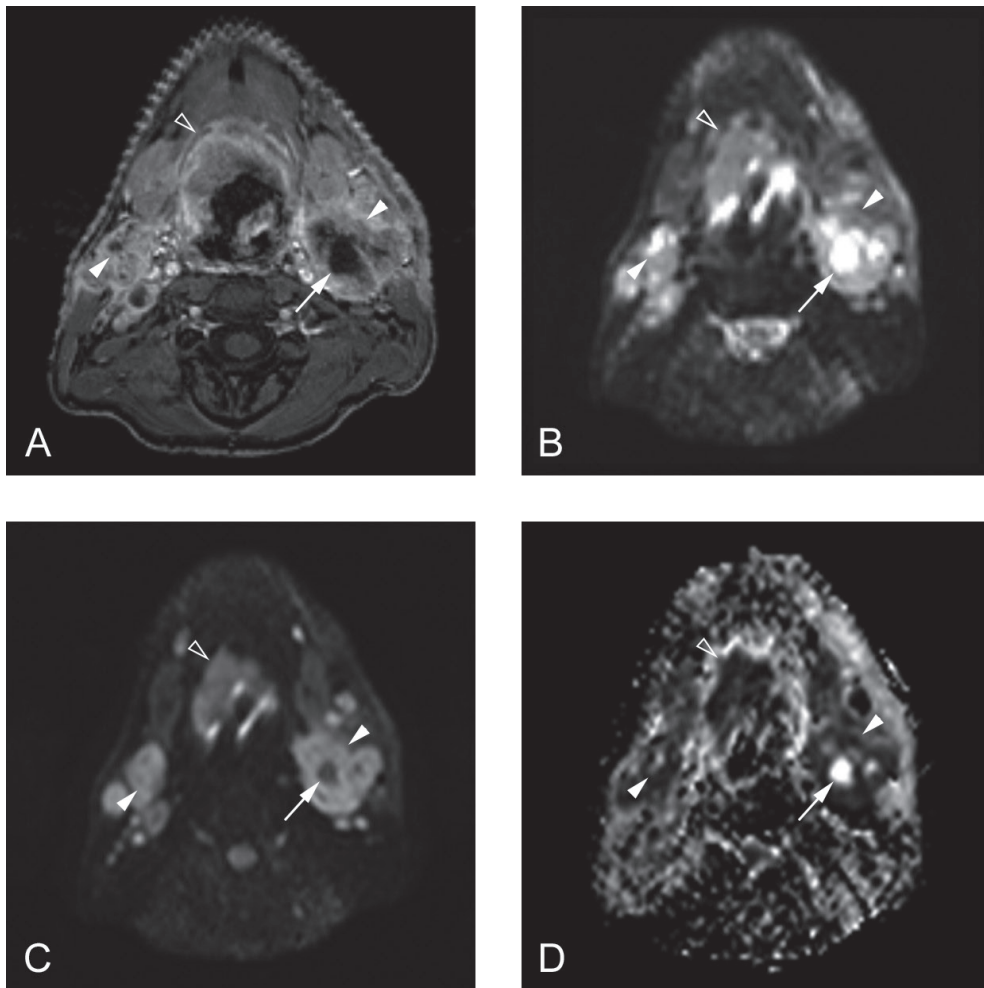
Diffusion-weighted MR images of a squamous cell carcinoma in the base of tongue of a 50-year-old male. (A) Axial T1-weighted gadolinium MR image shows primary tumor and malignant lymph nodes (arrowheads) and necrotic centre within the lymph nodes on the left (arrow). (B) The primary tumor (open arrowhead), lymph adenopathy on both sides (arrowheads), and the necrotic centre on the left (arrow) show hyperintense signal on spin-echo echo-planar DWI $b\ 0\ \text{s/mm}^2$. (C) The vital malignant areas remain hyperintense (arrowheads) on $b\ 800\ \text{s/mm}^2$, whereas the signal in the necrotic core is hypointense. (D) Apparent diffusion coefficient (ADC) map shows hypointense signal in the primary tumor and malignant lymph nodes, corresponding with a low ADC and a high signal in the necrotic core, corresponding with a high ADC.
